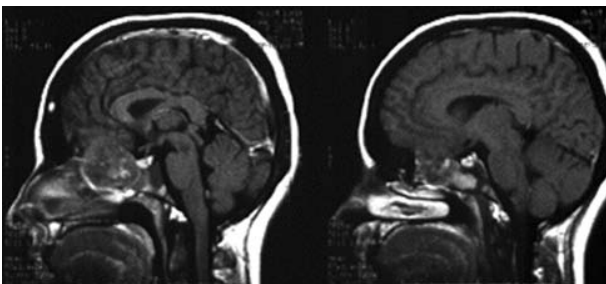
Sagittal post-contrast T₁-weighted magnetic resonance images showing peripheral fibroosseous part.
